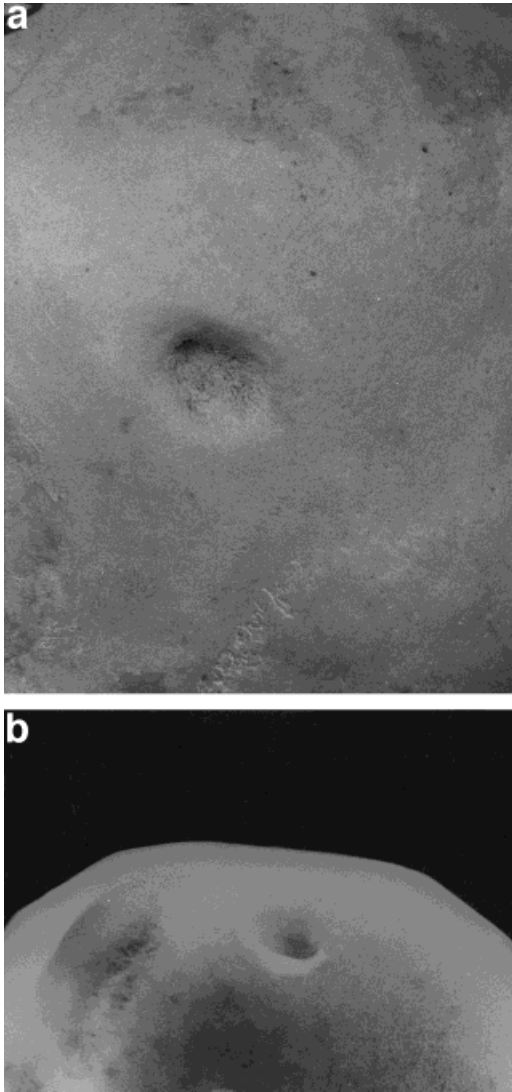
a: Left parietal with a healed fracture (15 × 12 mm). There was destruction of the external table, and the internal table had a small perforation (case MIT28C2, adult male). b: Radiograph of same case.
